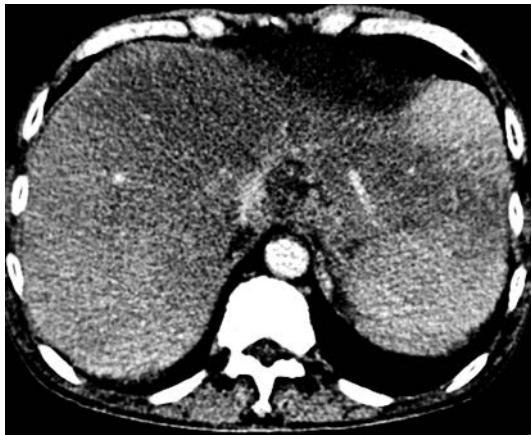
Axial contrast-enhanced CT: hypodense liver with heterogeneous enhancement.
